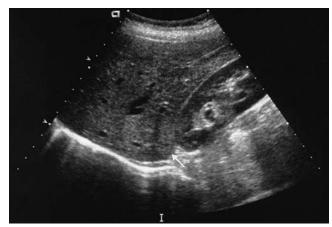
Sagittal sonogram of the right upper quadrant.
